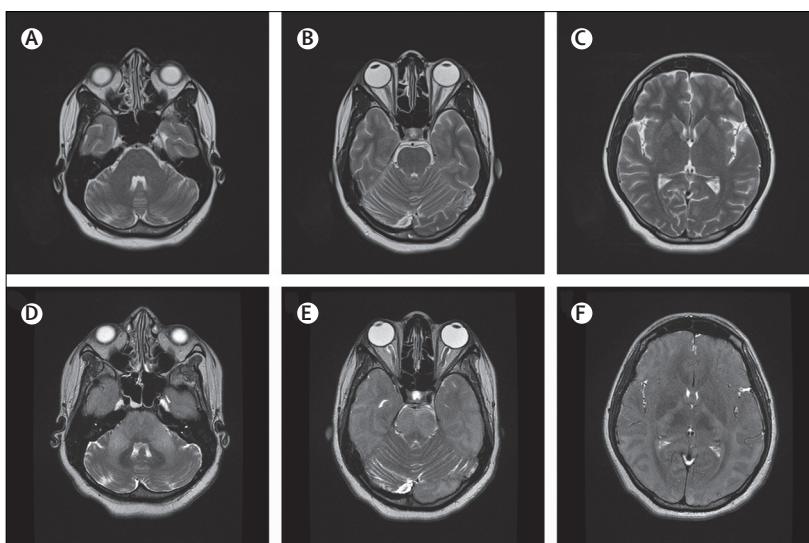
T2 weighted MRI scans from the time of admission and shortly before death. Normal findings early in the course of the disease at time of admission (A–C). Brain oedema and diffuse hyperintensity in the cerebral cortex, particularly in the occipital lobe, and throughout the brainstem shortly before death (D–F).
